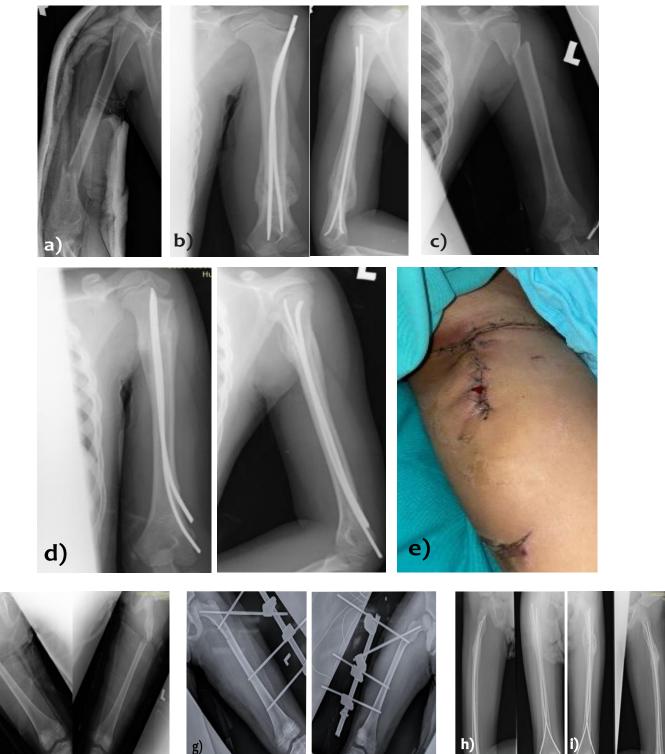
(a) Immediate and (b) three months postoperative radiograph of right humerus show a distal third humerus fracture that had achieved union, (c) Initial x-ray of left humerus demonstrates a proximal third humerus fracture that had united after three months post-surgery (d), (e) The patient sustained jagged laceration wound over proximal left thigh that communicated with the left proximal third femur fracture, at the same time she also had close right proximal third femur fracture as well (f), (g) Bilateral femur external fixation were performed for the femur fractures following the Damage Control Orthopadic principals while the upper limb fractures were immobilized using splints, (h) and (i) The anteroposterior and lateral radiographs of the bilateral femur taken three months after injury. Titanium Elastic Nails were inserted after patient was stabilized in intensive care unit. Radiographical union was demonstrated.
